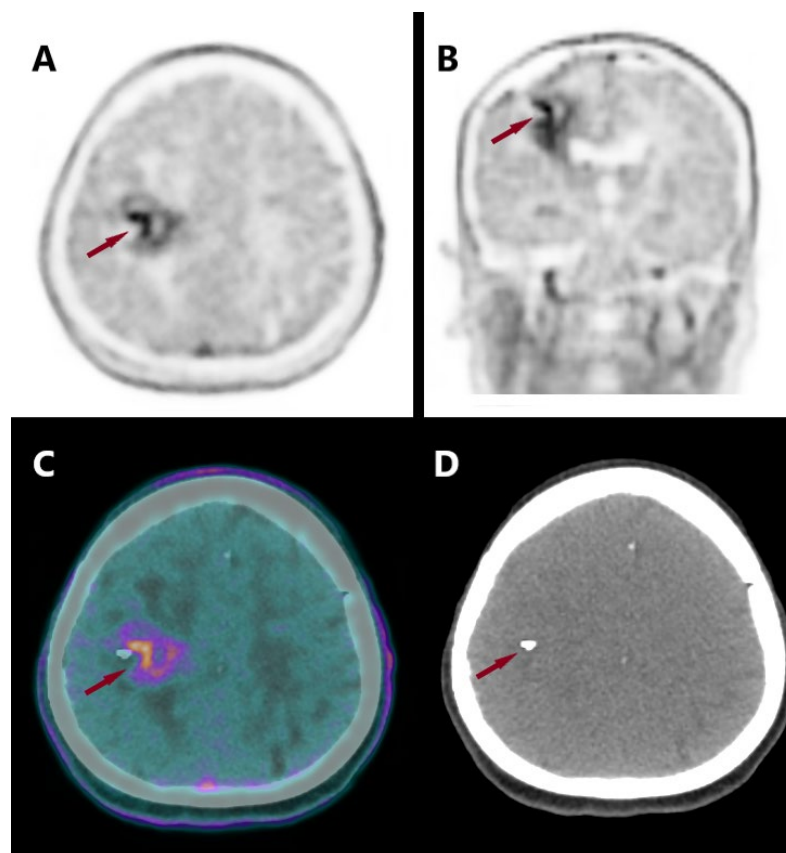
A 63-year-old female patient with relapsed glioblastoma WHO grade 4 IDH-wild type after surgical treatment for eleven months, radiotherapy for eight months, and adjuvant chemotherapy with temozolomide for four months. ^{18}F -FET PET/CT revealed a poly lobular lesion in the area of the precentral gyrus of the frontal right lobe, extending along the corona radiata to the corpus ventriculi lateralis, characterized by inhomogeneous accumulation of the tracer: moderately increased tracer accumulation along the periphery of the lesion and with the formation of “partitions” between metabolically inactive areas, which correspond to the zones of radiation necrosis. A lack of tracer uptake (red pointer) in its lateral part corresponds to postoperative changes and a maximum tracer accumulation in its dorsal part. CT (D) shows a metal clip in the area corresponding to the defect of tracer accumulation.
